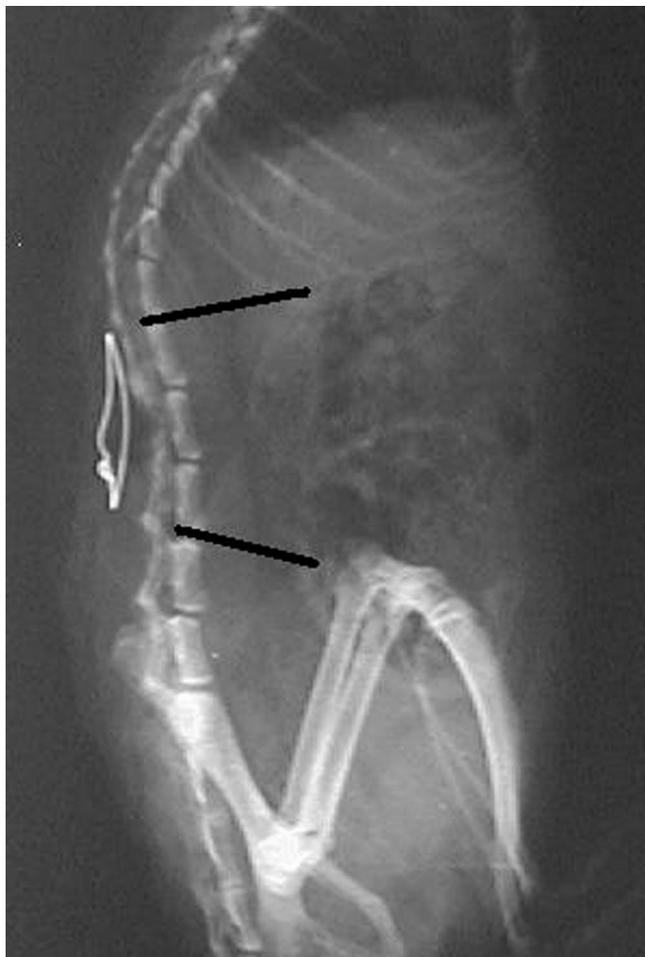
Measurement of the lordosis angle from the radiograph.
